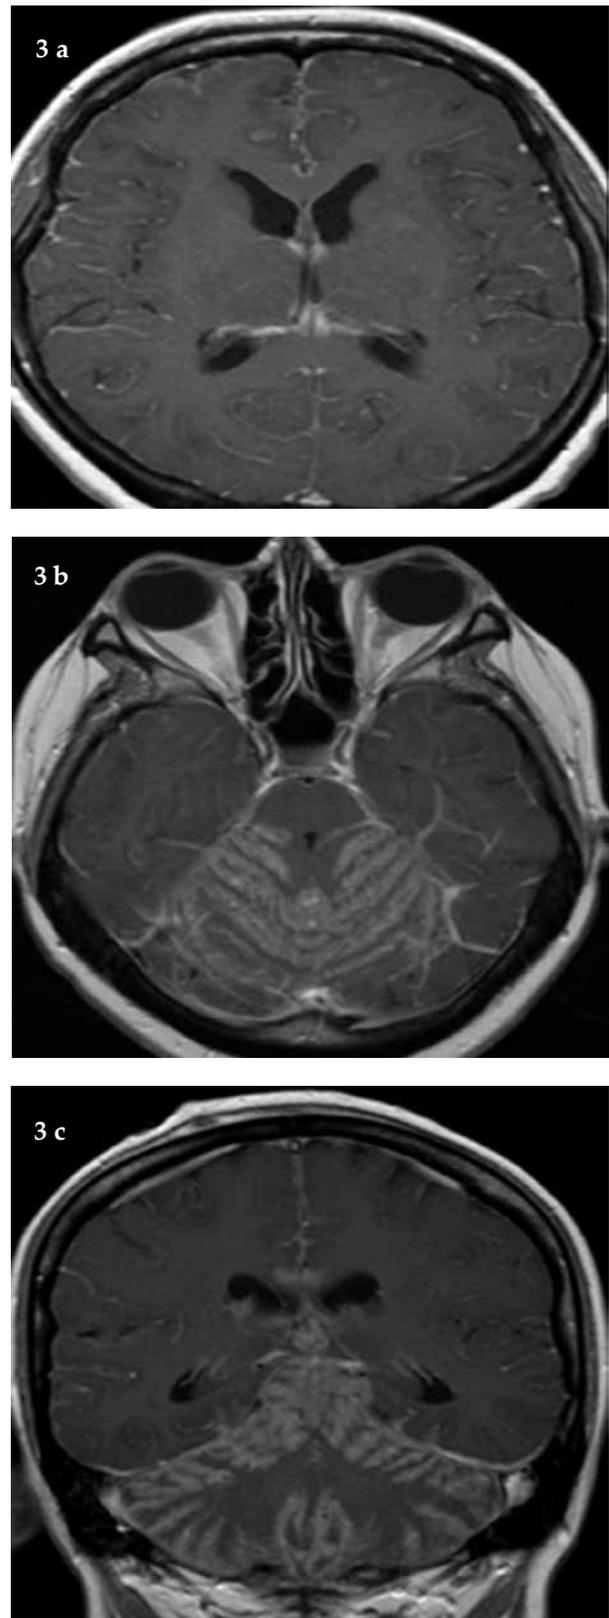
a,b,c) Postcontrast brain MRI images showing diffuse linear leptomeningeal enhancement of both cerebral (a) and cerebellar hemispheres (c,d), more prominently at posterior fossa on post-contrast T1W images.
